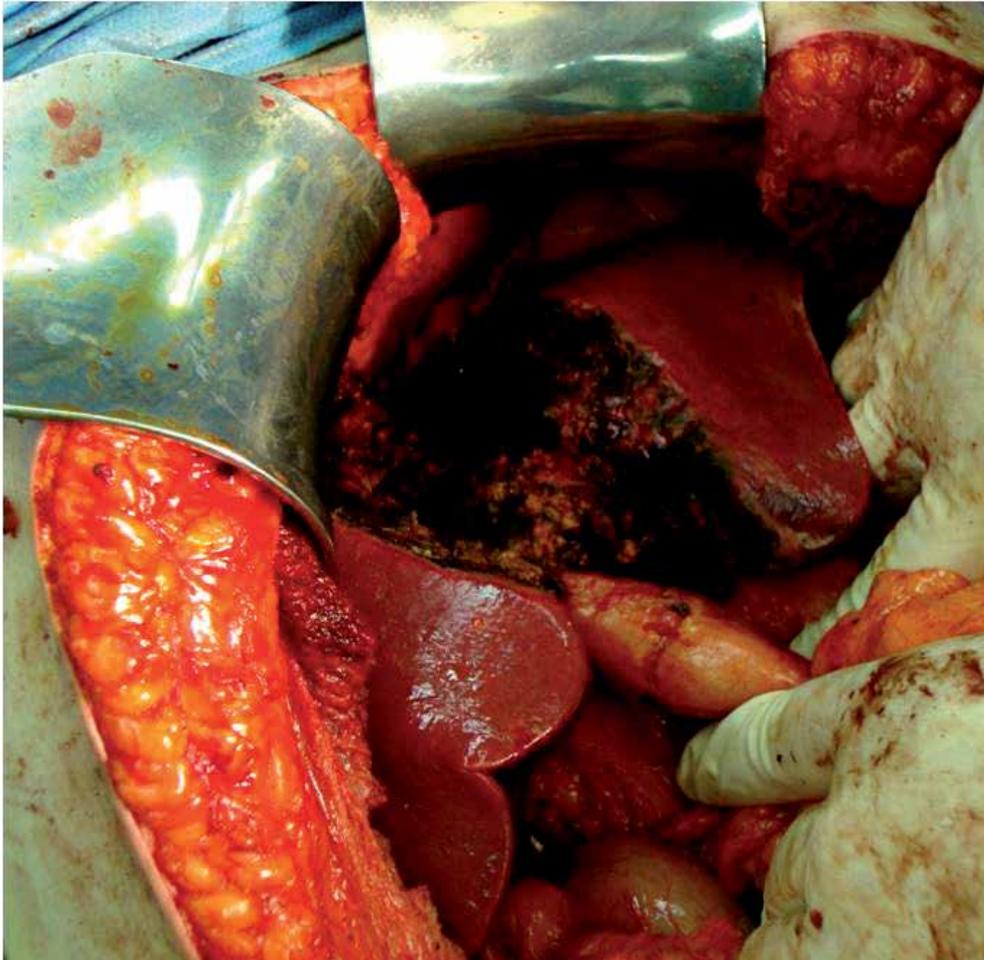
a, b: (a) CT of a large CRC hepatic metastatic lesion. (b) Nonanatomical resection of central CRC hepatic metastatic lesion.
